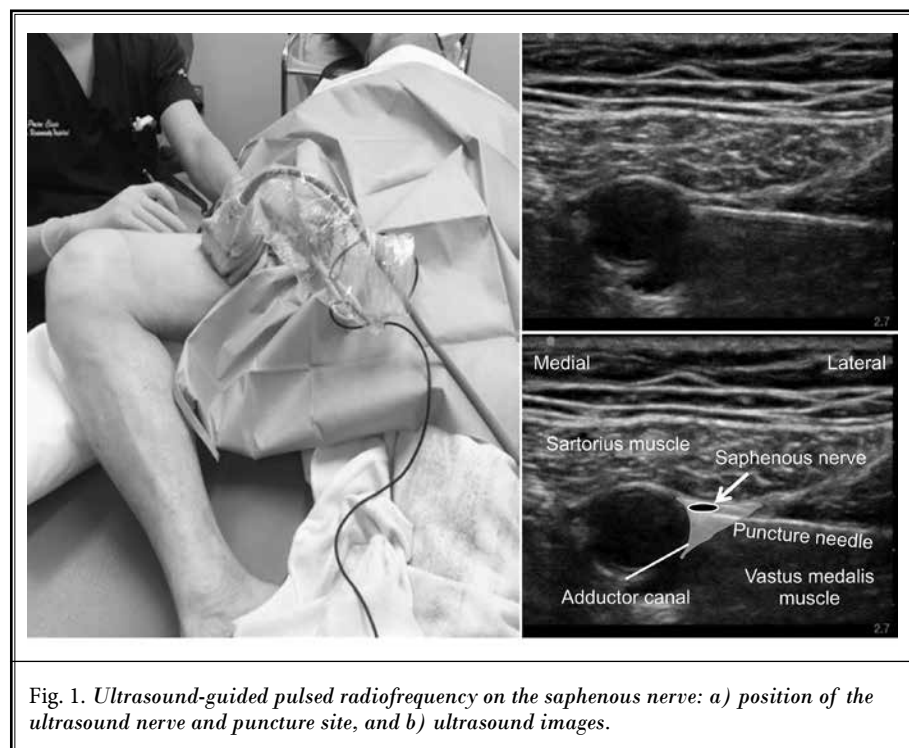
Ultrasound-guided pulsed radiofrequency on the saphenous nerve: a) position of the ultrasound nerve and puncture site, and b) ultrasound images.
